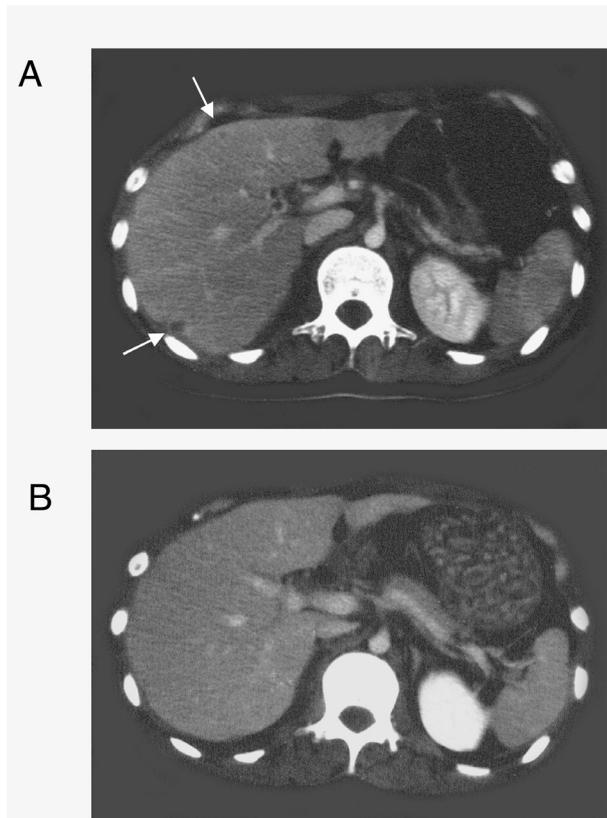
A An abdominal CT scan before micafungin treatment shows multiple small hypodense areas in Segments 5 and 7 (arrows). B An abdominal CT scan during micafungin treatment shows the disappearance of hypodense areas.
